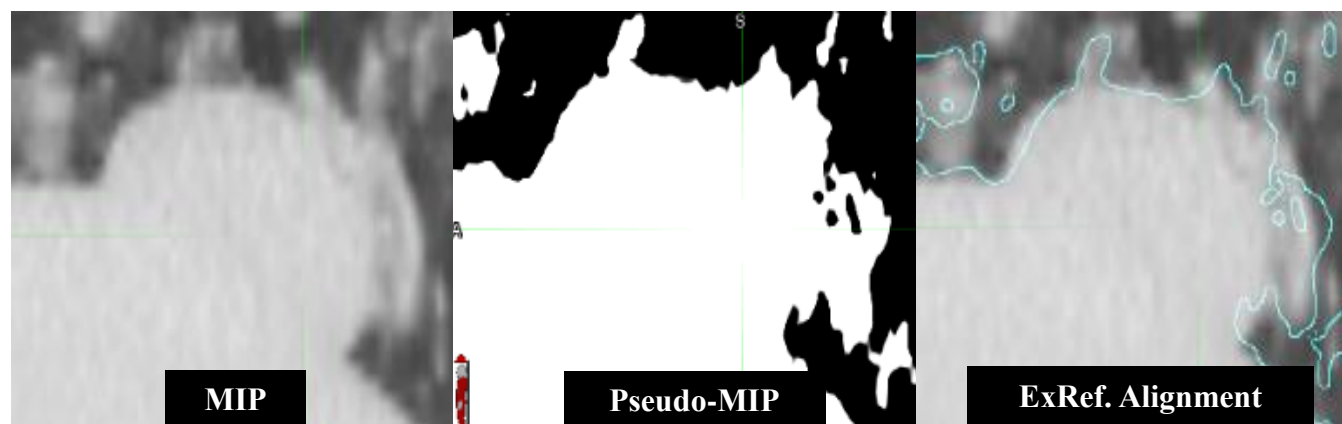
Figure A 18. Shows the maximum intensity projection (MIP), pseudo-MIP (PMIP), and the exhale reference (exRef) image registration between the two. Magnification of all three images is consistent. The PMIP is the CBCT obtained before treatment and has its Window/Level adjusted to have full brightness over the tumor’s entire respiration path; this mimics the concept of the MIP image. Blue lines in the exRef image represent the superior-edge matching between the MIP and PMIP. Shown to visually demonstrate the alignment method.
